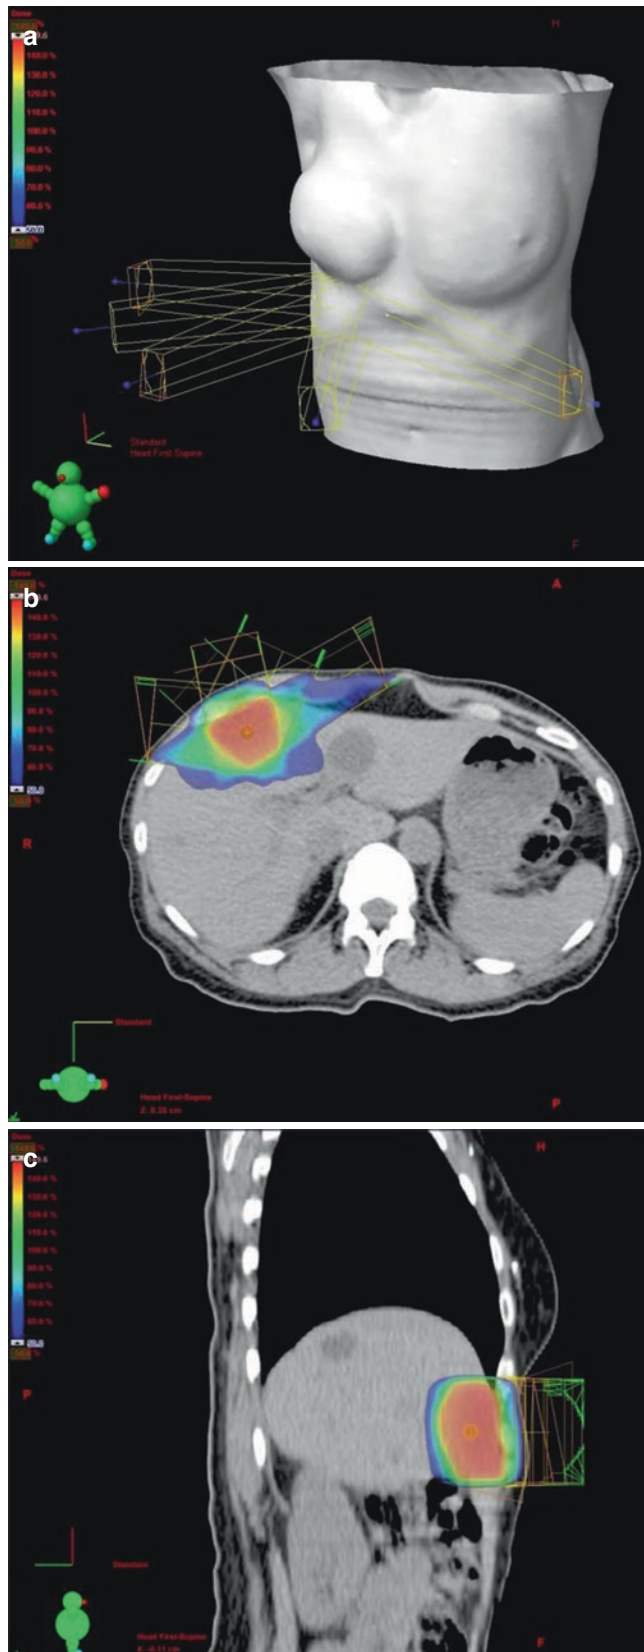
Stereotactic body radiotherapy plan of a liver metastasis with a dose prescription of 40.0 Gy in four fractions. The target definition is based on the movements captured with a 4D CT. The DRR (a) with the treatment fields. Transversal (b) and sagittal (c) views. The blue color corresponds to the 50% dose level. Eclipse™ Treatment Planning System
